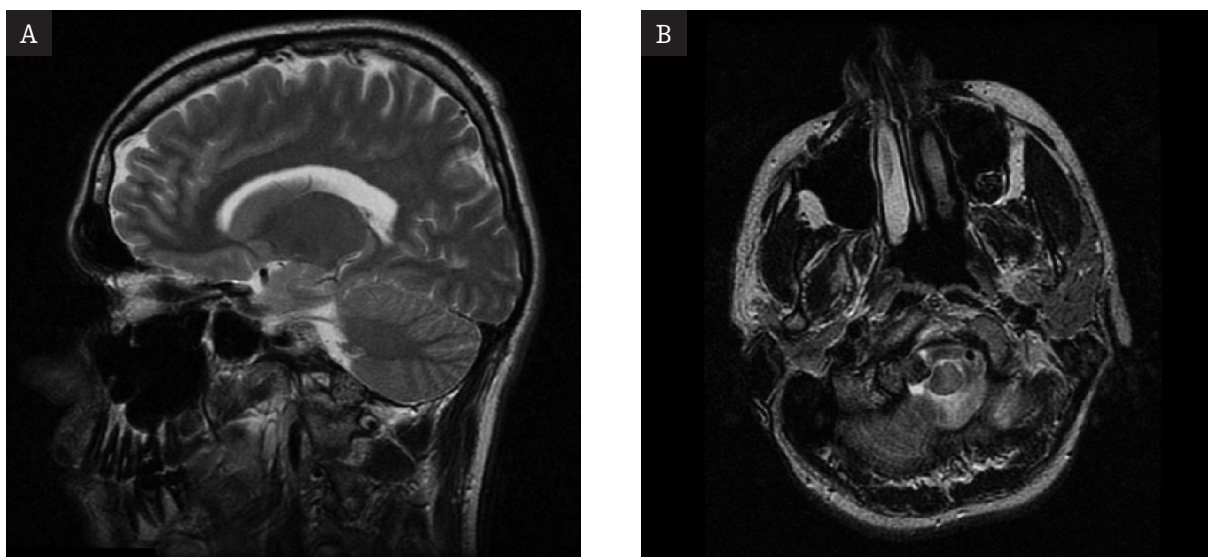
T2-weighted images show a low signal of the tumor; sagittal (A) and axial (B) cross-sections.
